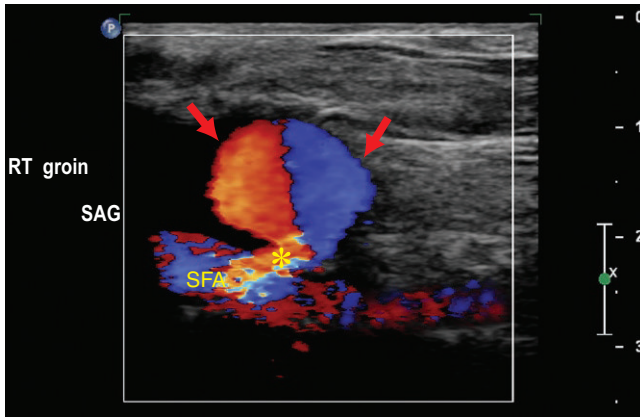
Long axis color Doppler image of right superficial femoral artery (SFA) demonstrates a collection of extravascular flow indicating a pseudoaneurysm (arrows). The neck of the pseudoaneurysm (*) is short.
